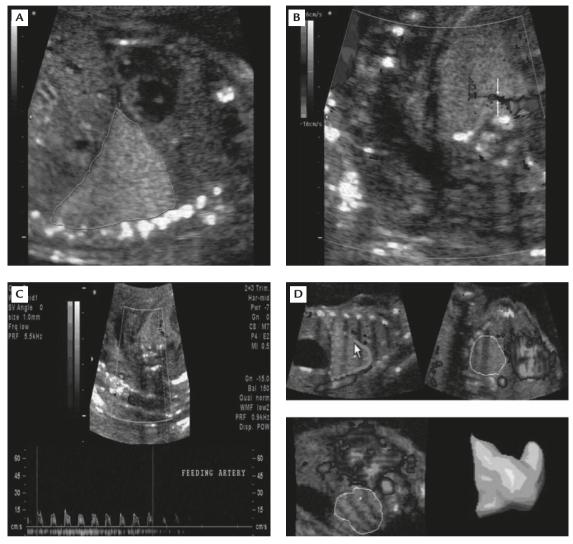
(A) Prenatal 2-dimensional ultrasound study of the fetal thorax in longitudinal section. The pulmonary sequestration is shown as high echogenic intensity at the left lower lobe of the fetal lung at 22⁺¹ gestational weeks. (B) Color Doppler ultrasound of the fetal thorax in transverse section. The feeding vessel originates from the descending aorta. The diameter of the feeding artery is 1.19 mm. (C) Color Doppler ultrasound of the fetal thorax in transverse section. The feeding artery is 11.85 cm/sec. (D) Three-dimensional measurement of the size of the pulmonary sequestration was 3.08 cm³.
